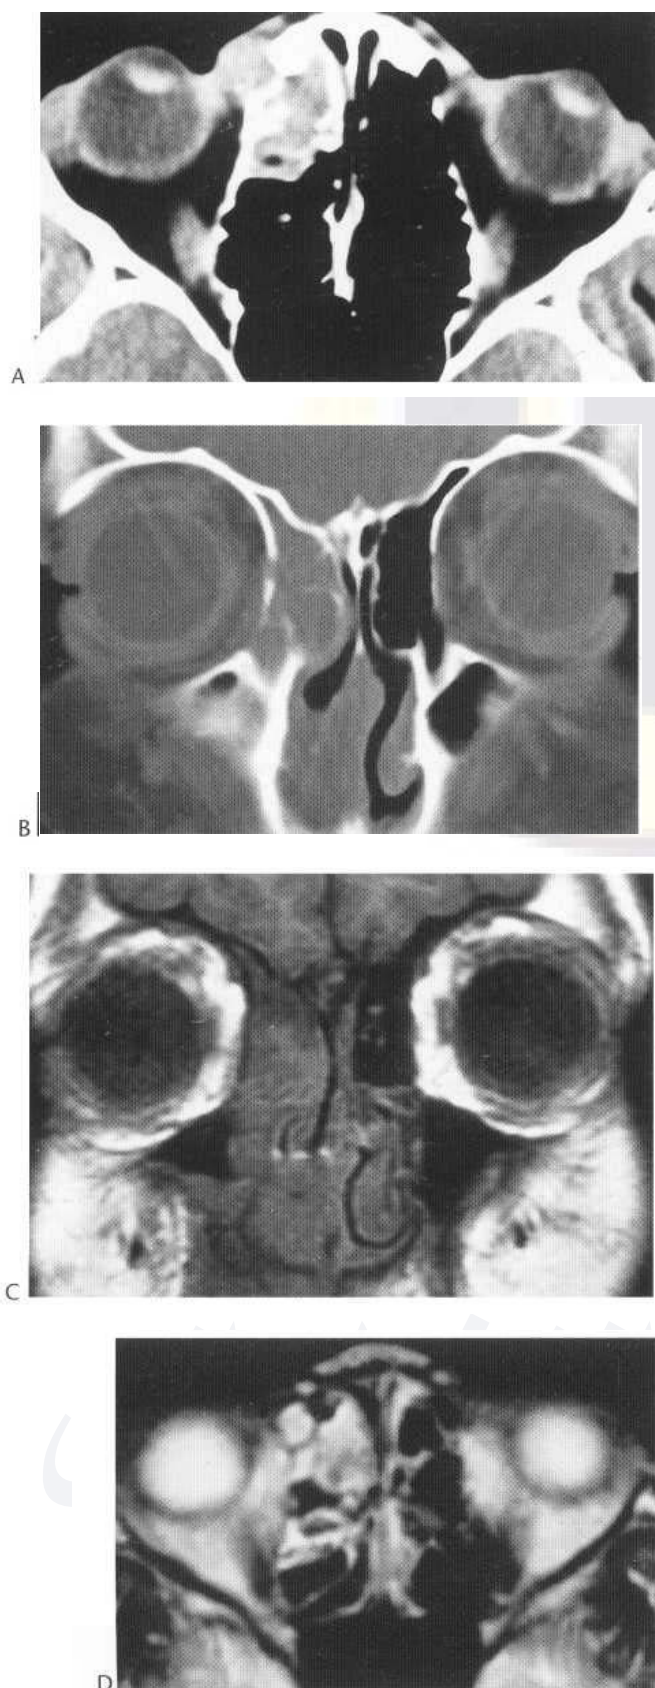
Nasolacrimal lymphoma. Enhanced axial (A) and coronal (B) CT images demonstrate right ethmoid mass extending to the lacrimal sac in the region of the right medial canthus. Non-enhanced coronal T_1 -weighted MR image (C) shows extensive involvement of right ethmoids and right nasal cavity; axial T_2 -weighted MR image (D) shows abnormal increased signal in right anterior ethmoid region.
